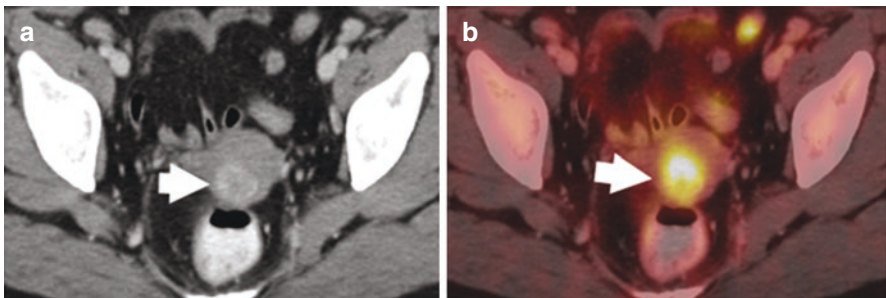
Intense tracer uptake is seen in an enhancing soft tissue lesion in the uterine wall suggestive of fibroid. [Any increased uptake in the uterus in a postmenopausal woman should be investigated and an ultrasound advised in the first instance]
